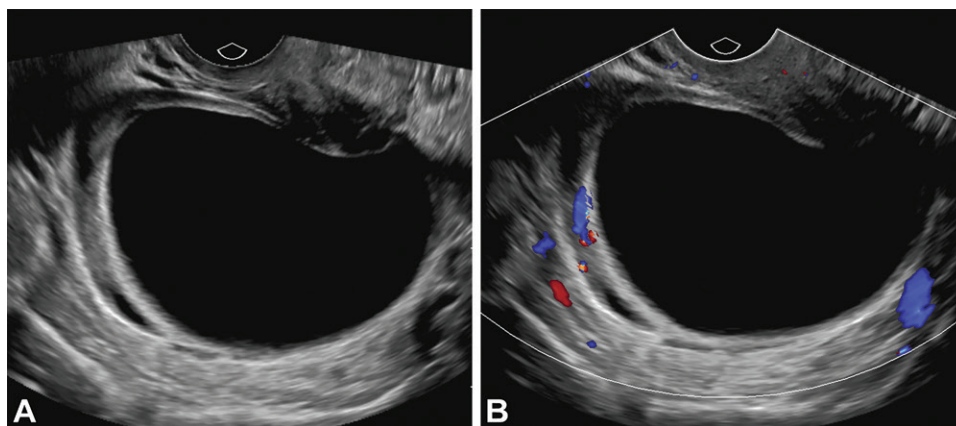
Simple cyst in a premenopausal woman (O-RADS 2). (A) Gray-scale US image shows a 7-cm simple cyst that is anechoic and unilocular and has a thin smooth wall. (B) Color Doppler US image shows no internal vascularity. This cyst resolved on a follow-up US image obtained 7 months later.
